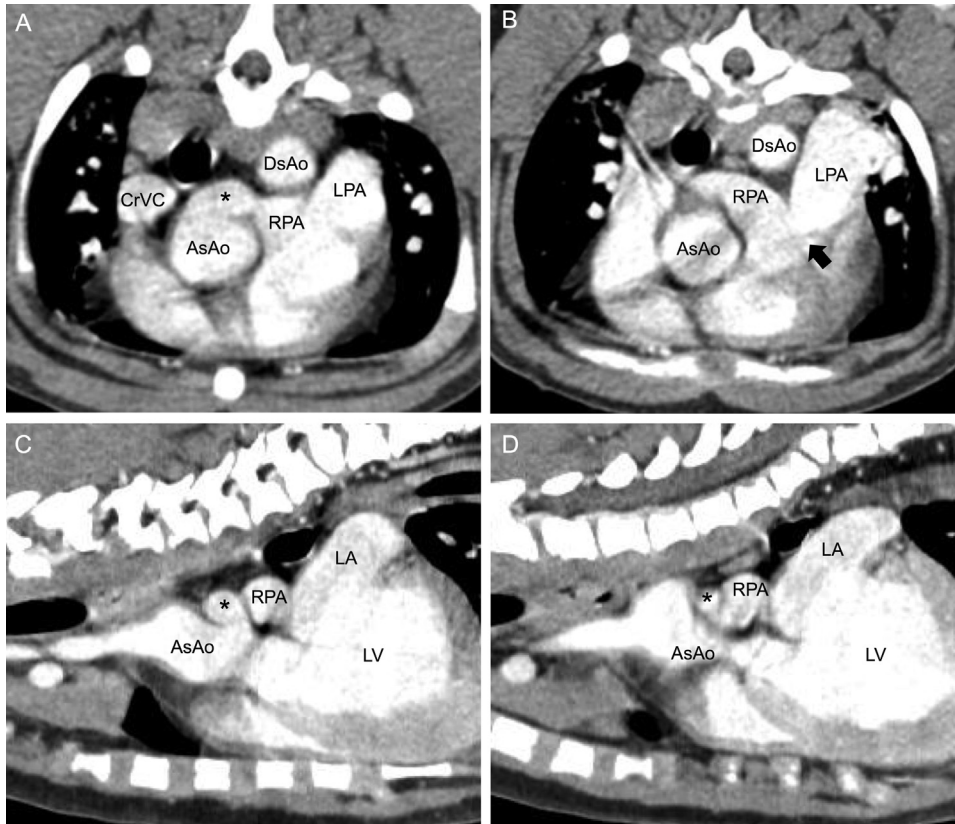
Computed tomographic angiography of the heart and major vessels. (A) Traverse plane at the level of the anomalous vessel (*asterisk*), which can be seen arising from the dorsal aspect of the ascending aorta (AsAo) and coursing toward the left to the right pulmonary artery (RPA). (B) Traverse plane highlighting the focal narrowing (*black arrow*) at the origin of the left pulmonary artery (LPA), indicating left peripheral pulmonary artery stenosis. Distally, the LPA is distended. In contrast, the RPA has a normal opening and size. (C) Sagittal plane centered at the origin of the anomalous vessel (*asterisk*). (D) Sagittal plane demonstrating the narrow insertion point of the anomalous vessel (*asterisk*) into the RPA. CrCV, Cranial vena cava; DsAo, descending aorta; LA, left atrium; LV, left ventricle.
